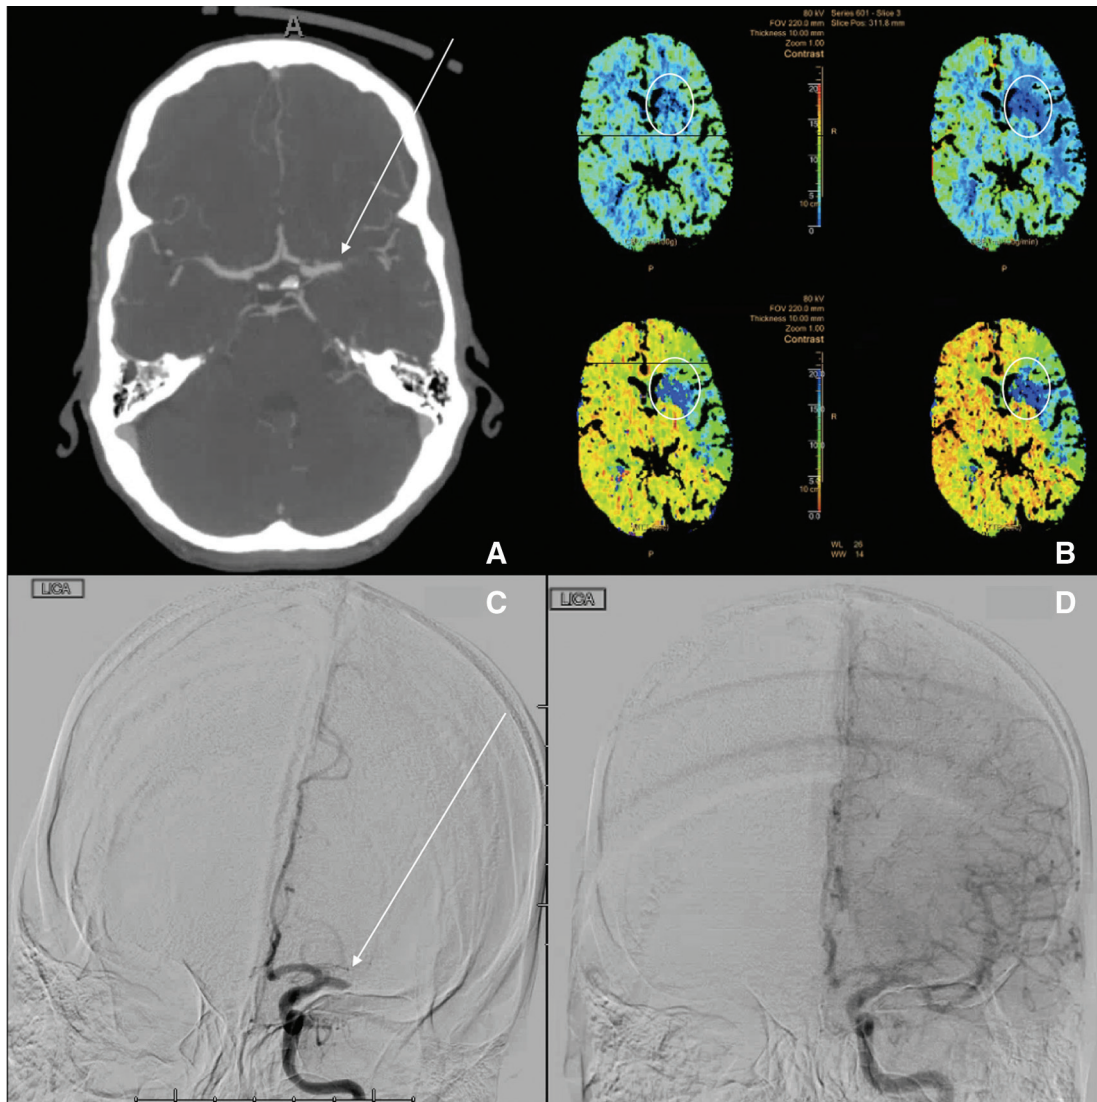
(A) Axial CTA revealing left M1 occlusion (white arrow). (B) Postprocessing CT perfusion revealing mismatch between CBV (top left) and time to perfusion (bottom right), indicating a significant penumbra. Note core infarct in caudate and basal ganglia, which appears to have low blood volume and high time to perfusion (white circles). (C) Anteroposterior view DSA revealing left M1 occlusion (white arrow). (D) DSA revealing TICI 3 recanalization of left MCA territory. CBV: cerebral blood volume; MCA: middle cerebral artery; TICI: thrombolysis in cerebral infarction
